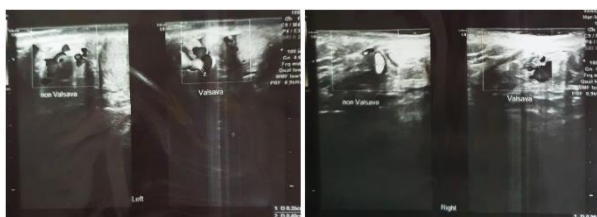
Ultrasound of left testis (Left) and right testis (Right)
